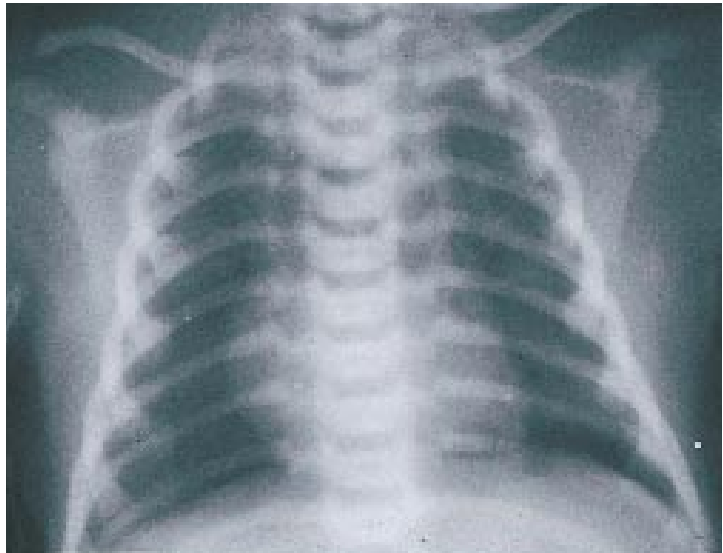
Radiograph of the chest of an infant with a translucent circular mediastinal shadow. If the radiograph is taken through the top of the incubator, it may give artifactual shadows such as this one caused by the hole in an Isolette™.
